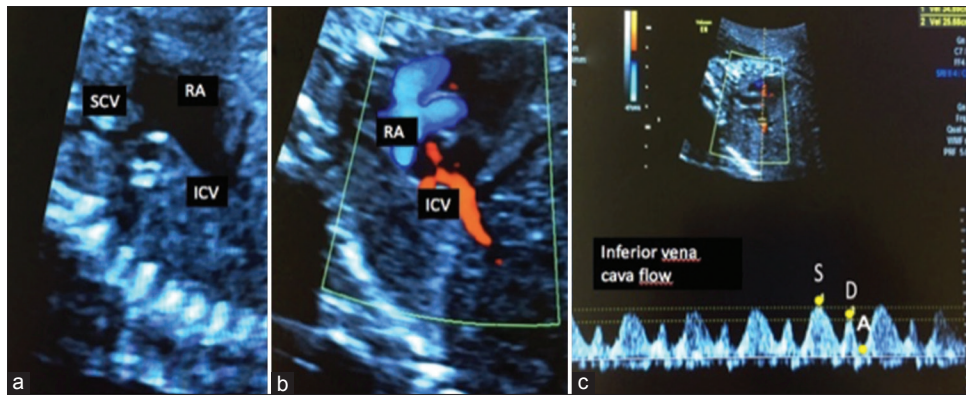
Normal Doppler waveforms of inferior vena cava Doppler obtained at sagittal view of superior and inferior vena cavas (a). The color Doppler filter was adjusted to lower pulse repetition frequency (b) and the pulsed Doppler sample located in the inferior vena cava with angle of acquisition smaller than 30° (c). RA: Right atrium; SVC: Superior vena cava, IVC: Inferior vena cava, S: Systolic wave, D: diastolic wave, A: Presystolic velocity (during atrial contraction)
